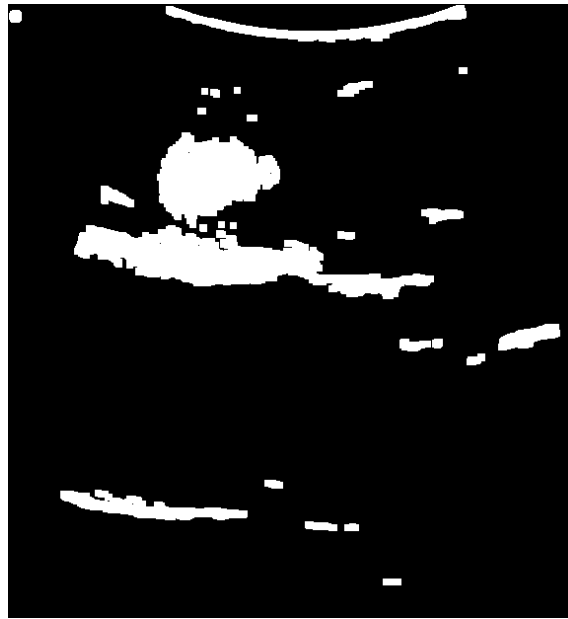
Ultrasound image after denoising.
